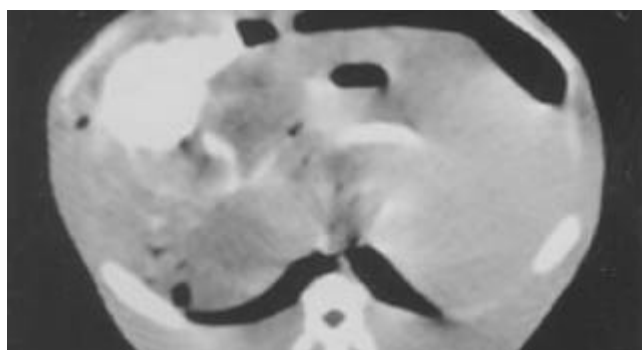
CT scan shows massive retention of iodized oil in tumor after TACE.
